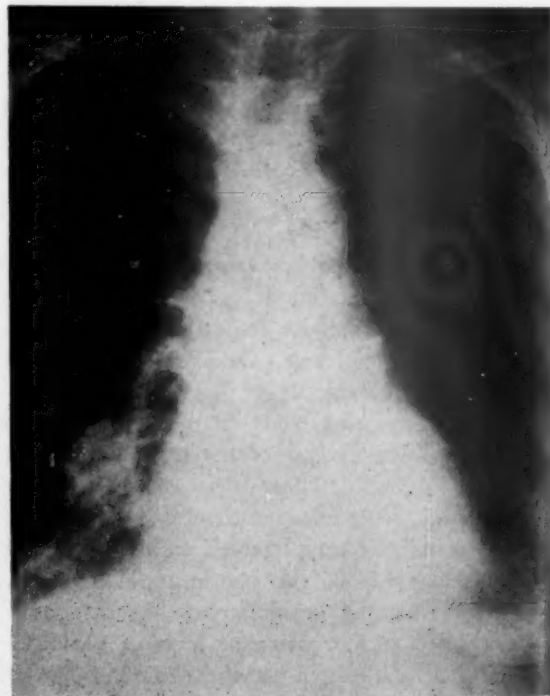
X-ray film of chest taken on March 9, 1955, showing condition becoming worse.
